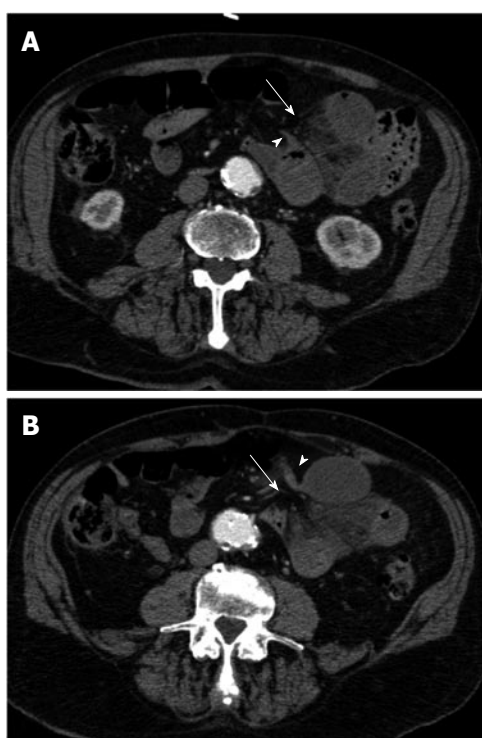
Multi-detector contrast-enhanced computed tomography. At retrospective analysis, a beak-like appearance (arrow-heads) of the closely apposed afferent (A) and efferent (B) jejunal loops can be appreciated along with the hernial orifice (arrow) in the periphery of the omentum. The peripheral location of the herniated loops and the absence of an overlying omental fat can also be appreciated.
